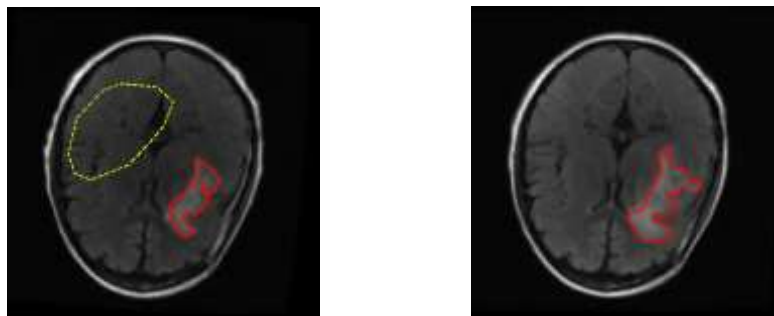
Sample tumor and normal regions where the red tumor regions are labeled by a radiologist and the yellow region denotes a normal region. FLAIR images at visit 1 (left) showing a progressed tumor at visit 2 (right).
